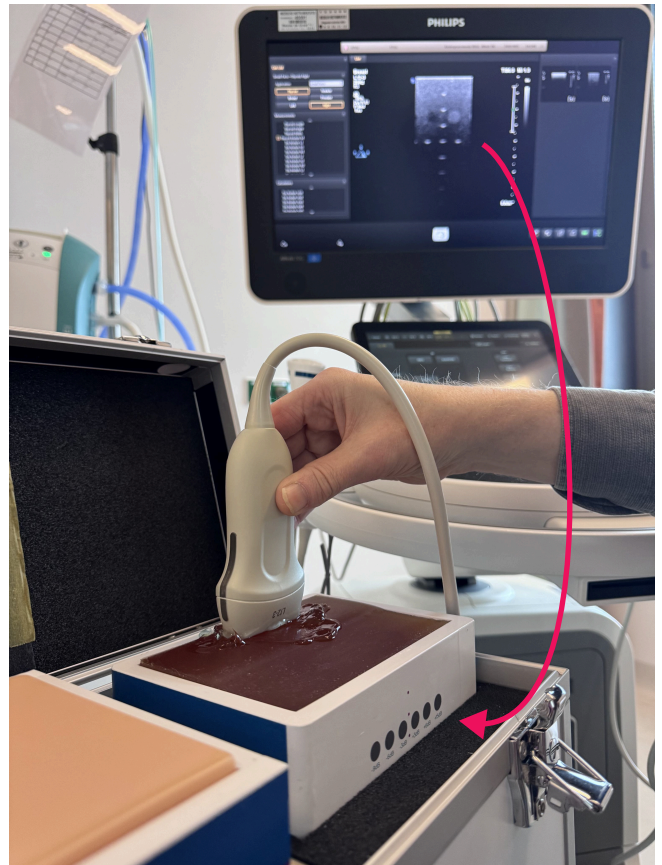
Sonography probe used by technician on test equipment
